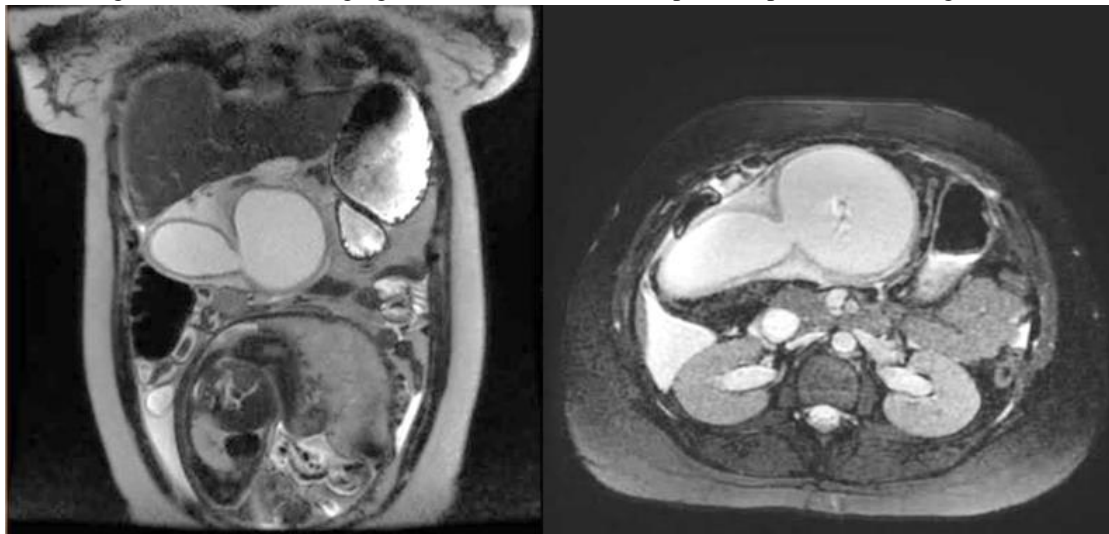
Coronal and axial section of magnetic resonance imaging showing: distended Gallbladder, enlarged and deviated towards the midline, V-Shaped torsion of the extrahepatic bilie ducts. A pregnant uterus can be seen in the pelvis.
